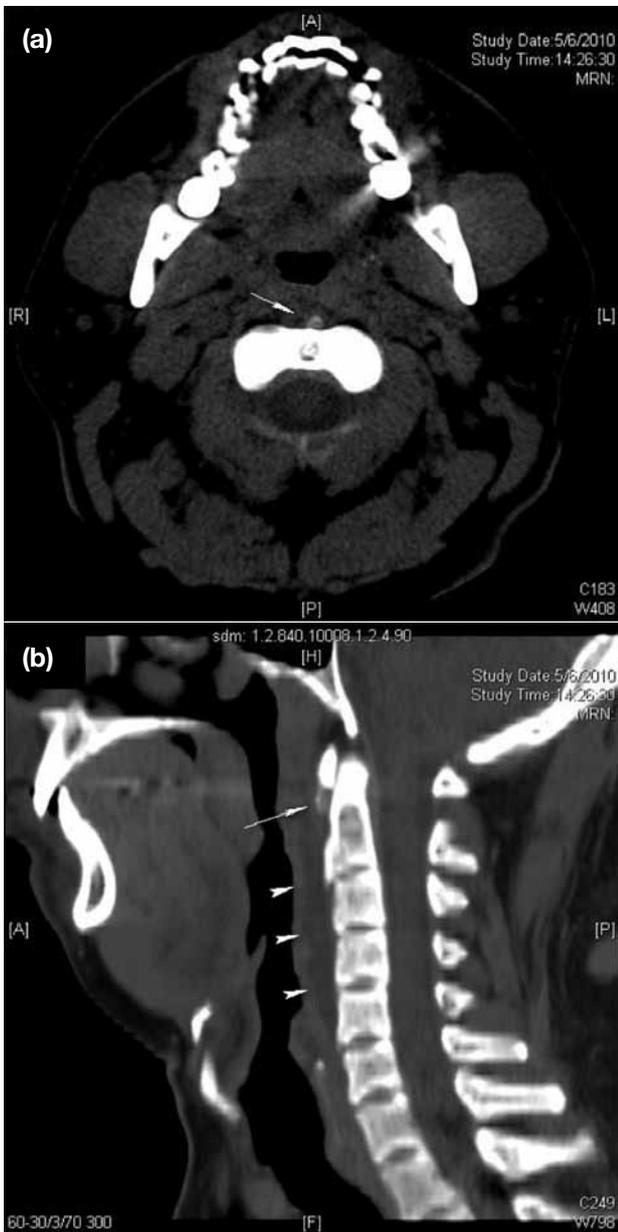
(a) An axial pre-contrast computed tomographic (CT) image at the level of C1, showing prevertebral calcification slightly off midline (arrow), compatible with a lesion within the superior portion of the longus colli tendon. (b) A sagittal CT image allows better demonstration of the calcification inferior to anterior arch of C1 vertebra (arrow). A fluid collection at the retropharyngeal space is also seen extending from C2 to C5 levels (arrowheads).
